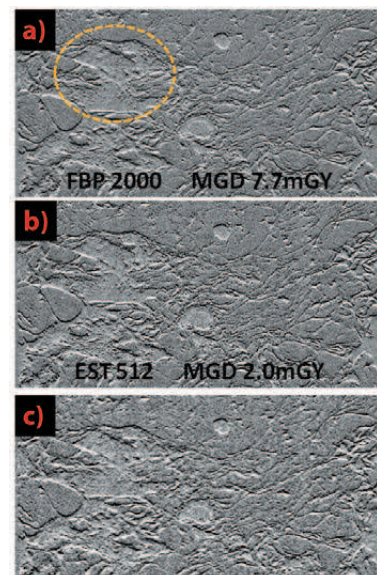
Image quality comparison of the phase contrast CT images of the whole breast (9 cm diameter), reconstructed using the conventional (Hamming filtered) FBP algorithm or the EST. a) A 92- μ m-thick sagittal slice of the FBP reconstruction using 2000 projections, b) EST using 512 projections or c) EST 200. The yellow ellipse indicates a tumour region. FBP 2000 and EST 512 have the highest image quality, EST 200 (with 1/10 of the dose necessary to reconstruct the FBP2000) still shows a high contrast.
